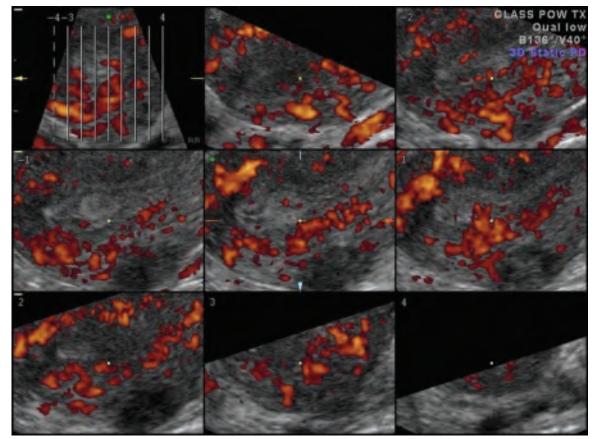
Tomographic ultrasound imaging is a 3D technique that permits sectional imaging in parallel planes. This is useful for identifying the number and location of polyps. Gray scale and power Doppler intensities can be displayed simultaneously
